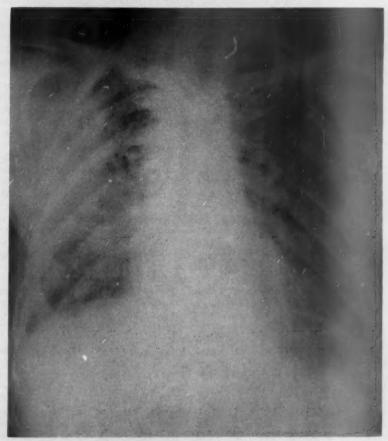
December 19, 1955. Chest x-ray shows linear and patchy infiltration in both lungs and conglomerate infiltrations in right lung.
